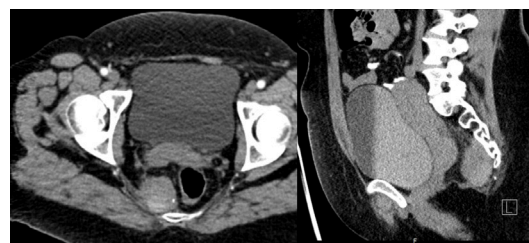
Axial and sagittal postcontrast CT images showing heterogeneous enhancement of the nodular lesion.
